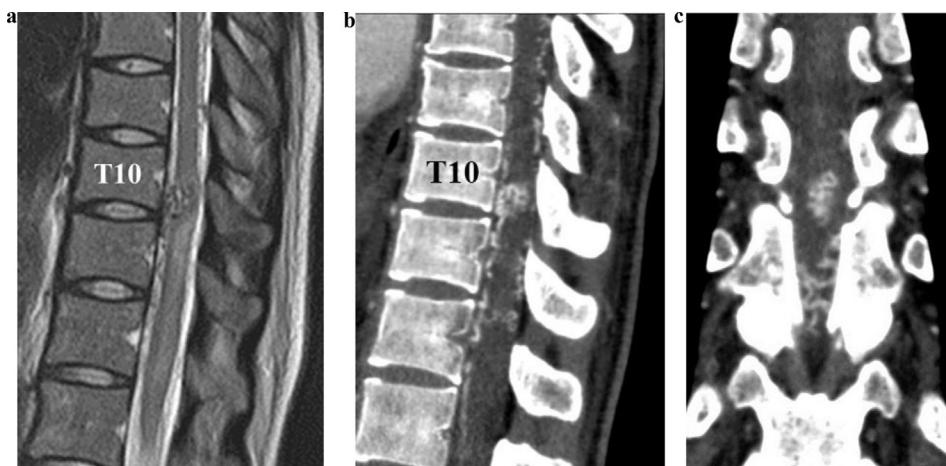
(a) MRI of the lower thoracic spine before treatment. Sagittal T2-weighted image shows serpentine flow voids (congestive venous network) posterior to the thoracic spinal cord, with abnormal intramedullary signal intensity at the T10 level. Edema (high intensity) of the lower thoracic spinal cord is also seen. (b, c) Contrast-enhanced CT angiography of the lower thoracic spine before treatment. Sagittal and coronal image shows abnormal, dilated vessels along the thoracic spinal cord at the T10–11 level and a high-density mass thought to be the abnormal A-V shunt.
